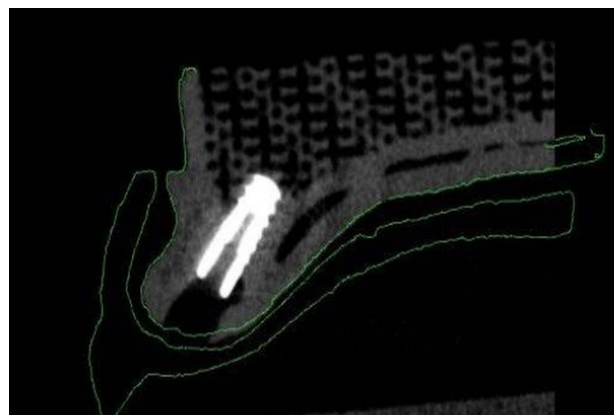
Sagittal view of the postoperative CBCT scan in Blue Sky Plan. Green represents the tomographic guide, gray denotes the maxillary model, and white indicates the placed implant
